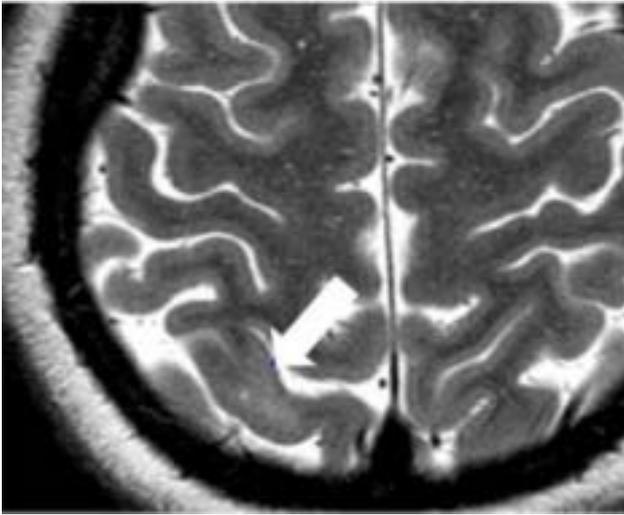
T2 weighted, axial MRI using a surface coil to demonstrate a small area of focal cortical dysplasia characterized thickening of a gyrus and indistinct gray-white junction (arrow).
